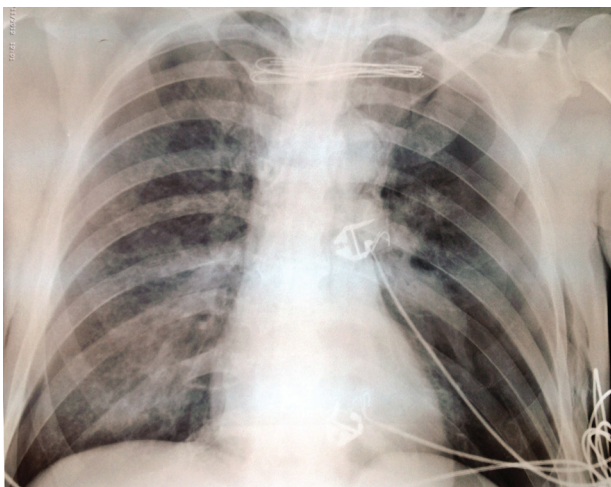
The chest X-ray shows bilateral pneumothorax, pneumomediastinum, and subcutaneous emphysema
